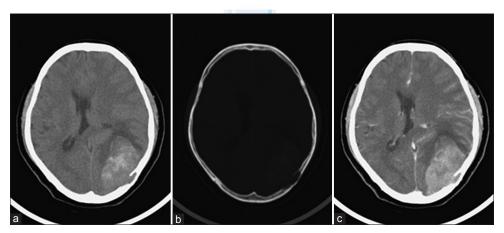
Brain computed tomography. (a) Precontrast imaging. Heterogeneous hyperdense mass lesion at left occipital area. (b) Bone window imaging. Skull bone erosion at left occipital area. (c) Postcontrast imaging. Enhanced mass lesion at left occipital area
